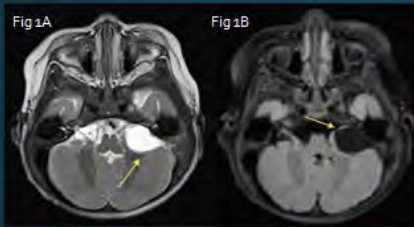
(A) T2 weighted imaging at the level of the posterior fossa demonstrates a left cerebellopontine angle hyperintense lesion. There is mass effect on the adjacent structure. (B) Corresponding FLAIR sequences shows the lesions anteriorly displacing the facial and vestibulocochlear nerves as they exit through the internal auditory canal. The lesions suppresses on FLAIR, which supports the diagnosis of an arachnoid cyst.
